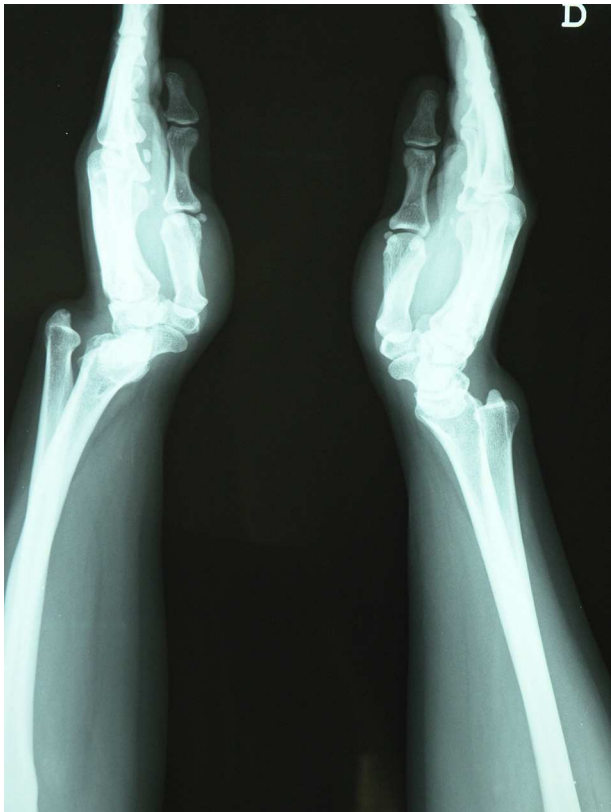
Lateral X-ray of both wrists.
